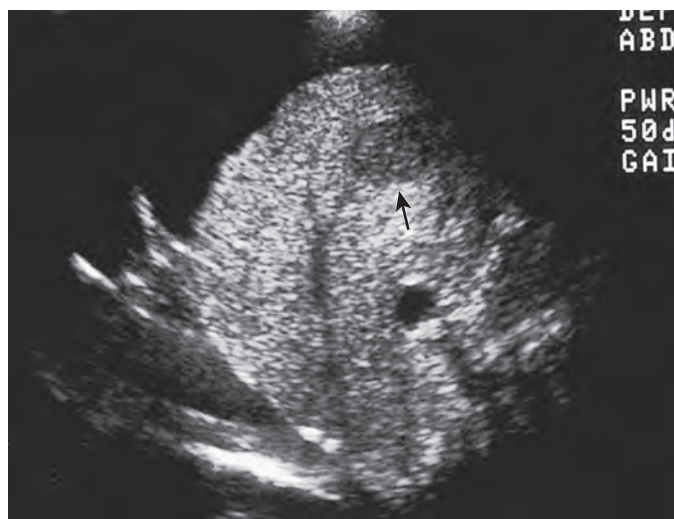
Ultrasonography of a 42-year-old man with cirrhosis and portal hypertension. Gray-scale ultrasound of the liver in the longitudinal plane revealed a small, shrunken liver with heterogeneous echotexture consistent with cirrhosis. There is also a considerable amount of perihepatic ascites and a 2-cm hypoechoic nodule in the right hepatic lobe anteriorly (arrow). The mass underwent biopsy with ultrasound guidance by an intercostal space through the ascites. Fine-needle aspiration revealed hepatocellular carcinoma. There were no hemorrhagic complications.
